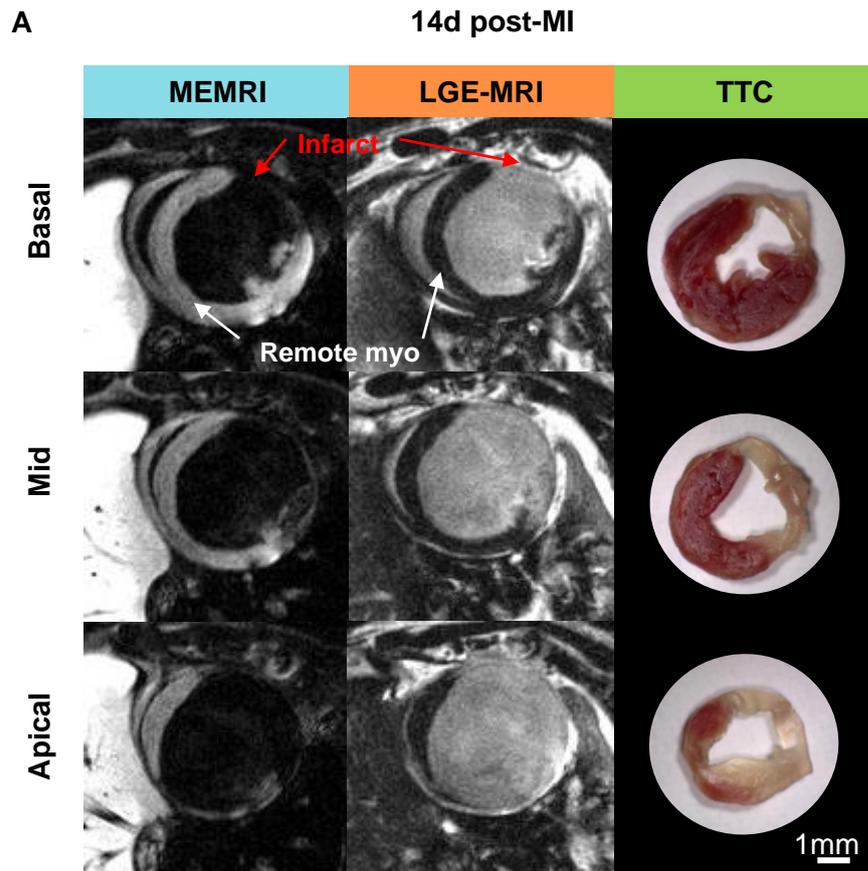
Direct comparison of MEMRI and LGE-MRI at 14d post-MI.
